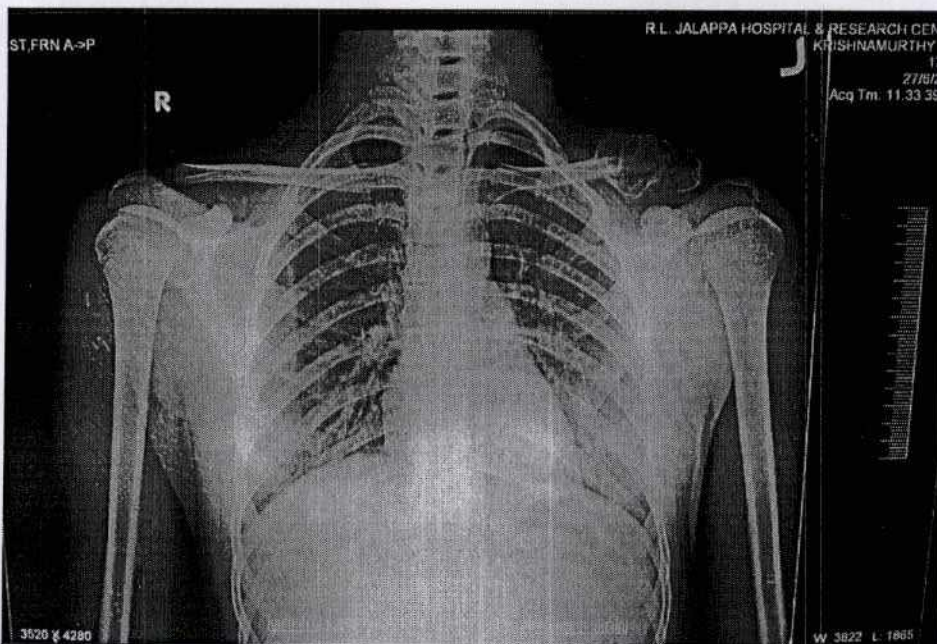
Radiograph showing cystic expansile lesion bounded by a thin layer of bone at the lateral end of the left clavicle.
